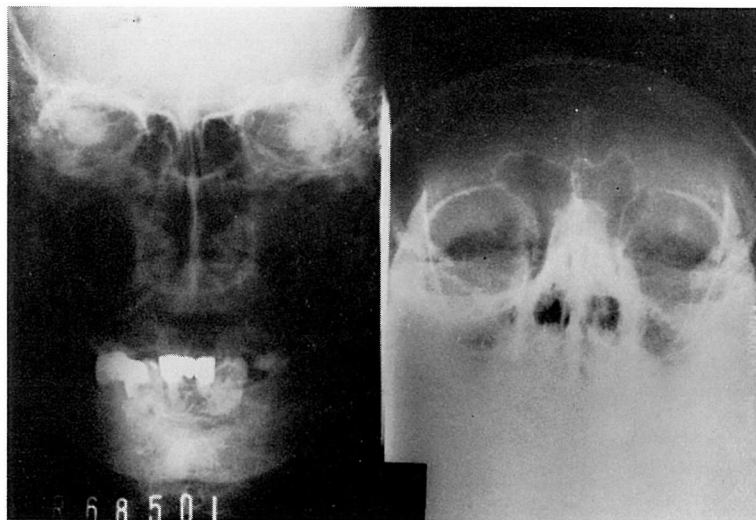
X-ray of the nose and paranasal sinuses, showing a slight cloudiness on the left nasal cavity.
